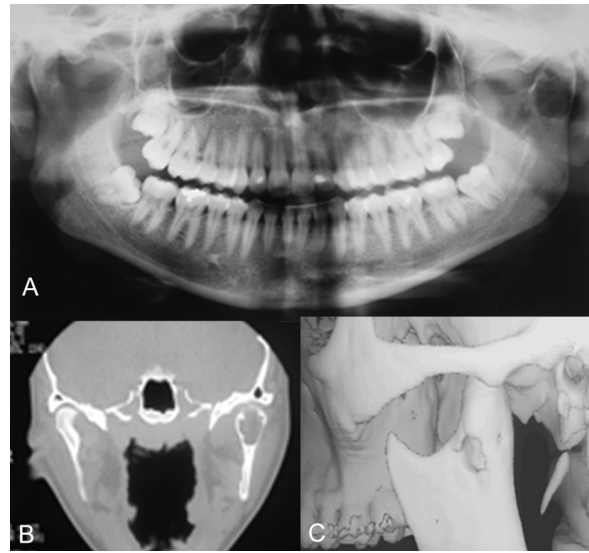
A - Panoramic radiography showing a radiolucent lesion in the left mandible condyle. B - Helical CT (coronal view) showing thinning of buccal and lingual cortical bone in the left condyle. C - Helical CT showing the rupture of the lateral cortex of the left mandible condyle.
